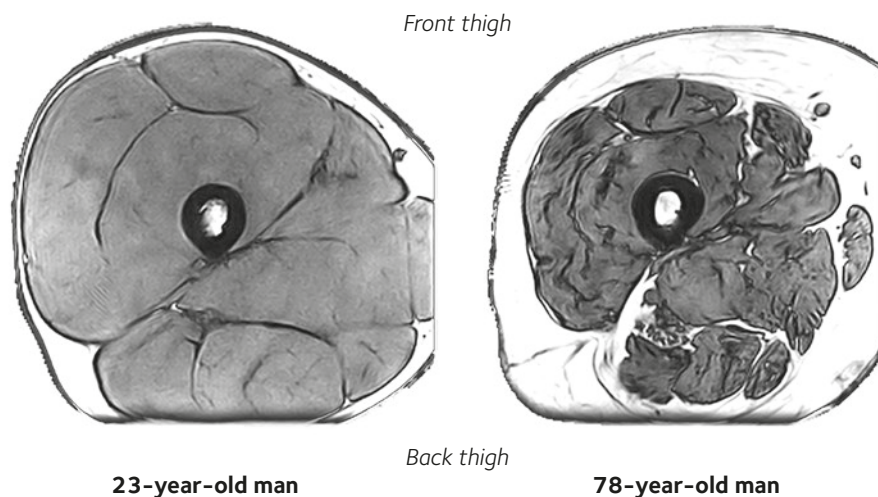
Mid-thigh magnetic resonance image of a young (left) and older man (right). The femur bone is in the middle creating a black ring. Muscle tissue is shaded grey, and fat tissue is white. The quadriceps muscles of the anterior thigh are typically 30–35% smaller for 75+ compared with 25-year-olds.
